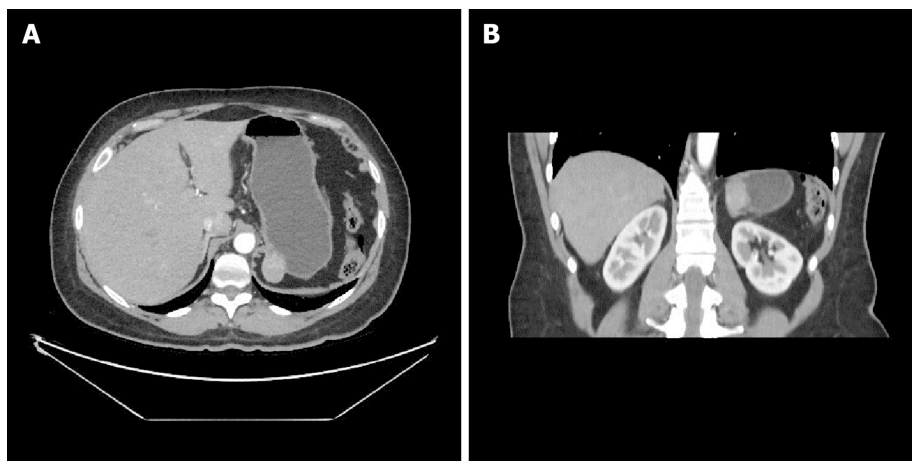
Preoperative abdominal computed tomography scan with intravenous contrast administration: A: Transverse; B: Coronal.
